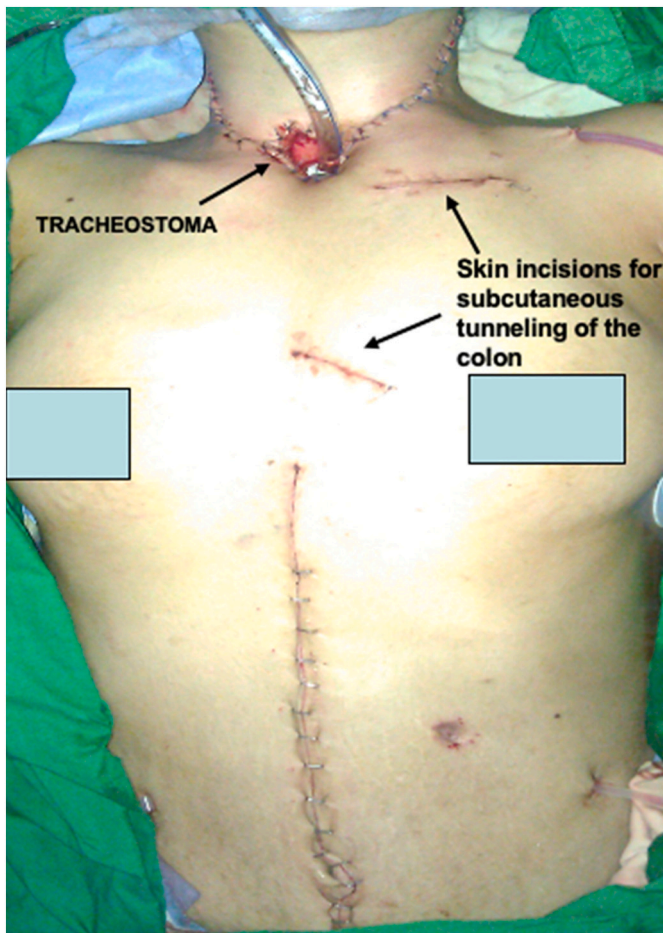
Tracheostoma at lower neck and closed two skin incisions along left parasternal line.
